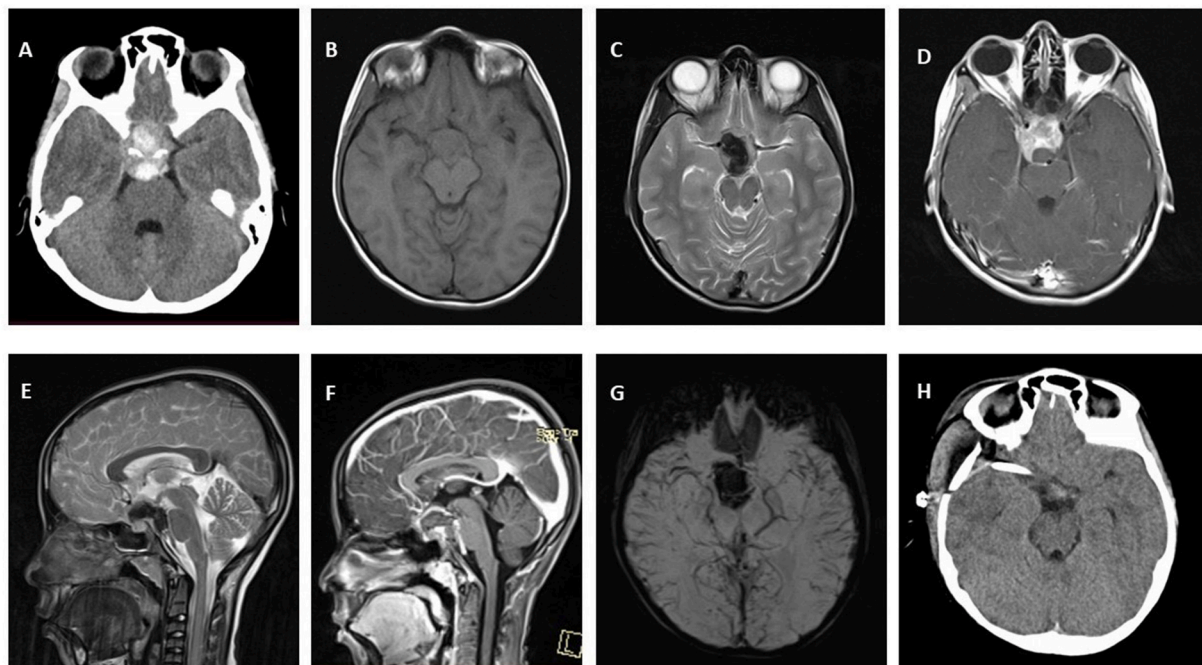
A- Axial section of non-contrast CT head showing a hyperdense SOL in suprasellar region.
